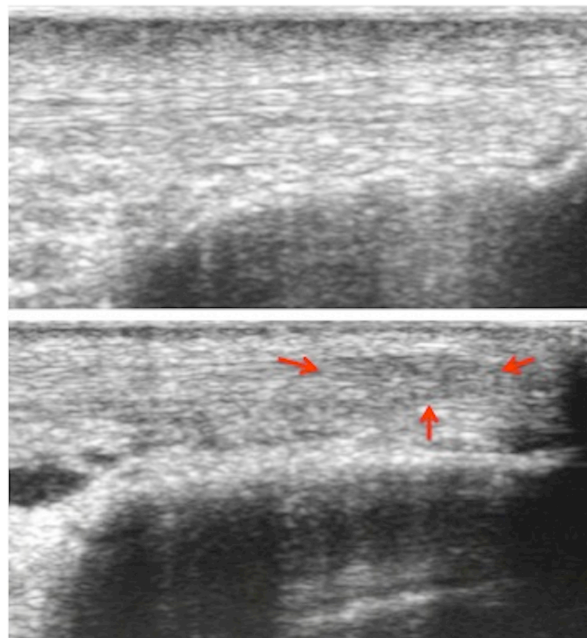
Ultrasound images of patellar tendon normal (above) and with abnormalities (below). The arrows indicate a hypoechoic area.
